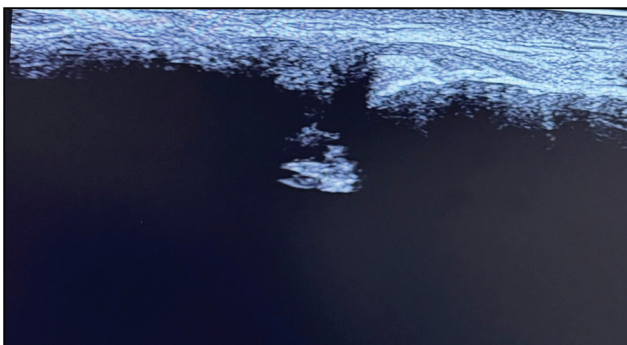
Ultrasound-guided image showing the acromioclavicular joint
